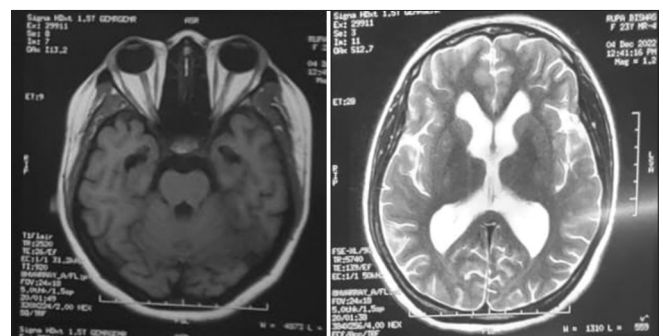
Magnetic resonance imaging brain - T1 image on the left showing no parenchymal signal change in pons. Similar to non contrast computed tomography brain, a communicating hydrocephalus is noted in T2 image with dilatation of horns of lateral ventricle
